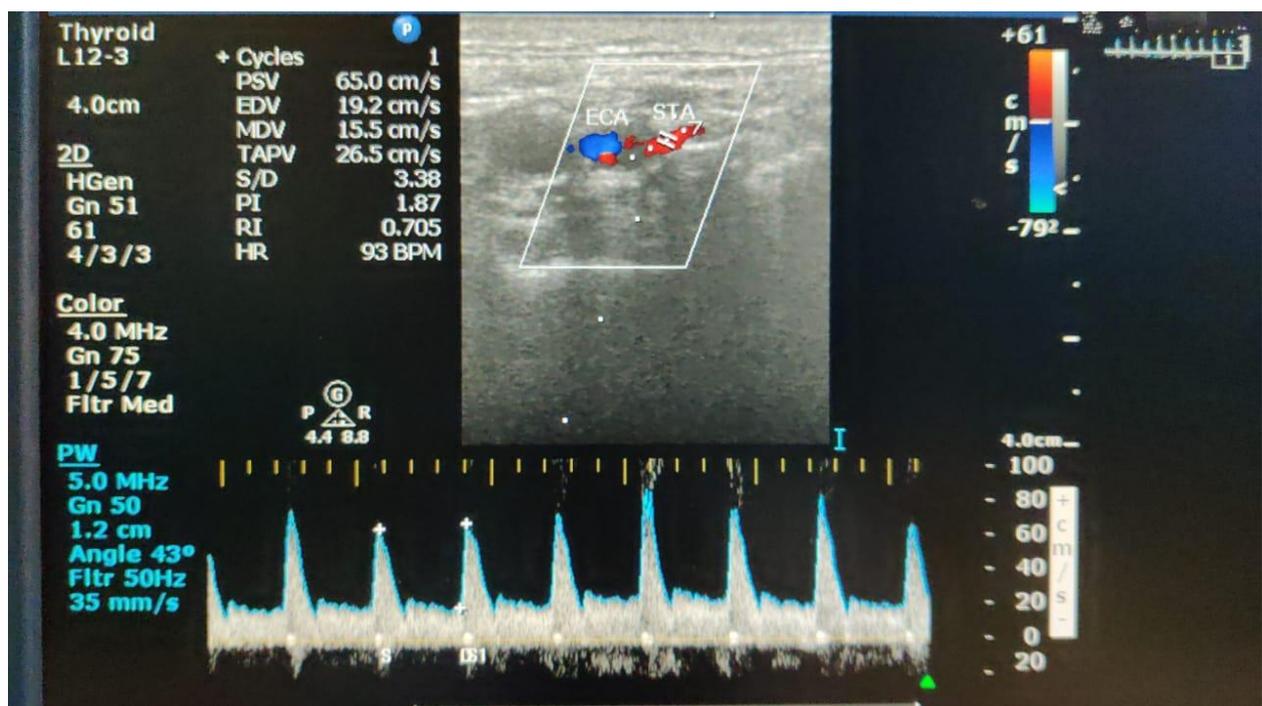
On USG there was a large fairly well-defined, taller than wider heteroechoic lesion with peripheral wall calcification noted involving the right lobe of thyroid. On Doppler interrogation there is increased vascularity and raised Doppler indices[PSV-65 cm/sec, PI-1.87, RI-0.7]-TIRADS-4
